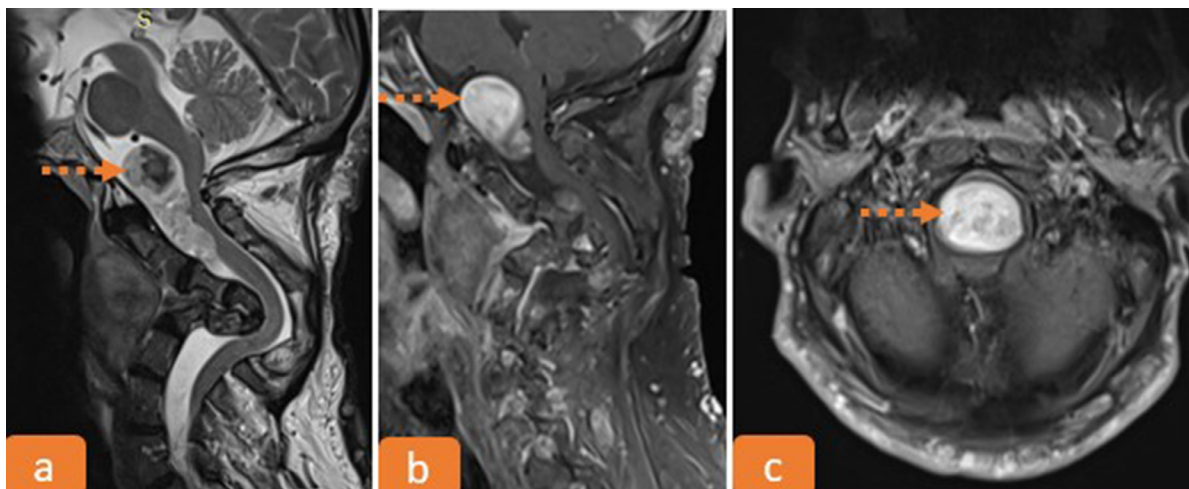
Cervical spinal cord MRI, sagittal T2-weighted image (A); T1 Fat suppression postcontrast enhancement in sagittal section (B) and axial section (C), showing a large neurofibroma compressing the closed bulb and the cervical cord (---▶). A scoliotic deformation of the cervical spine is also noted.
